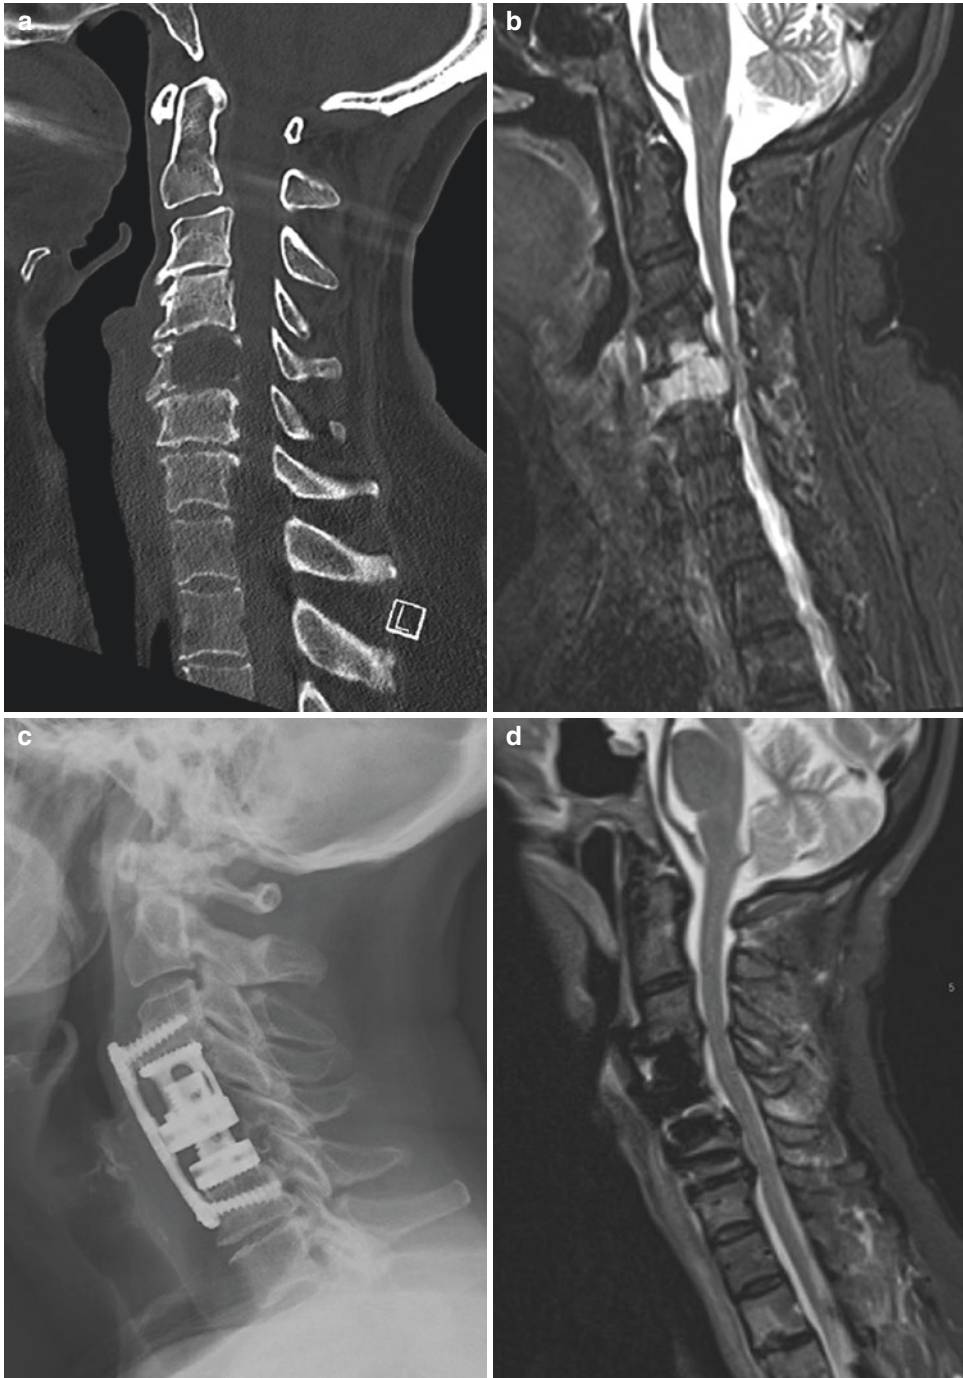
68-year-old woman with metastatic renal cell carcinoma and neck pain. Baseline cervical spine CT (a) shows a large lytic metastasis destroying most of the C5 vertebral body. Baseline cervical spine short tau inversion recovery (STIR) MR image (b) shows the metastasis occupying the entire C5 vertebral body, extending superiorly to C4 and posteriorly into the left epidural space. On images not shown, the mass effaced the C4-C5 and C5-C6
